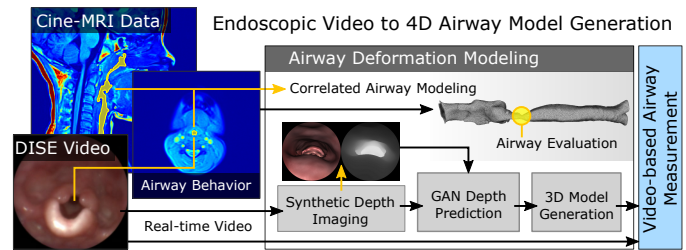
Overview: Cine-MRI airway scan data is integrated with endoscopic DISE video to train a GAN network to predict depth images for 3D reconstruction. The reconstruction is then used to evaluate dynamic 3D airway restrictions and obstructions to reduce the number of required Cine-MRI scans.
